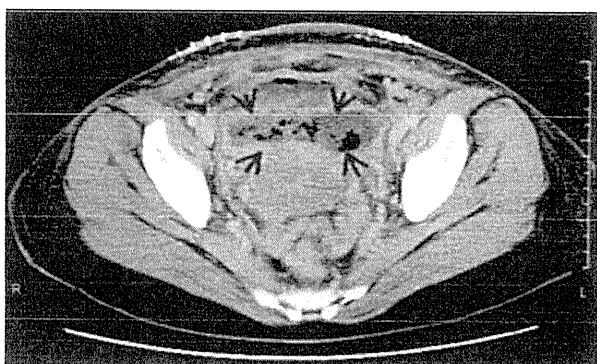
Computed tomography scan obtained on the fourth day. An abscess was detected at the site where the hematoma had formed (arrows).
